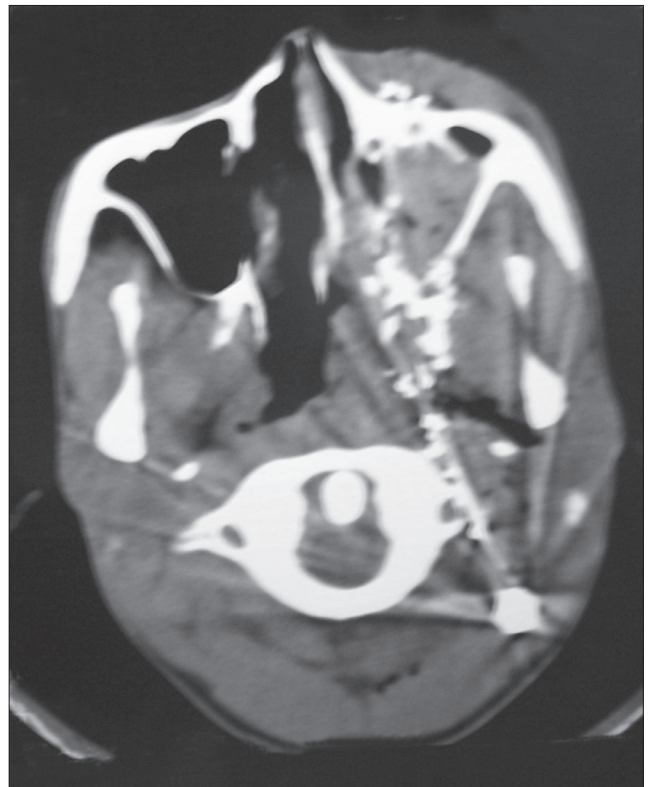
Axial computed tomography section of the neck indicating position of the missile on the lateral aspect of the cervical vertebrae and fluid in the left maxillary sinus.
